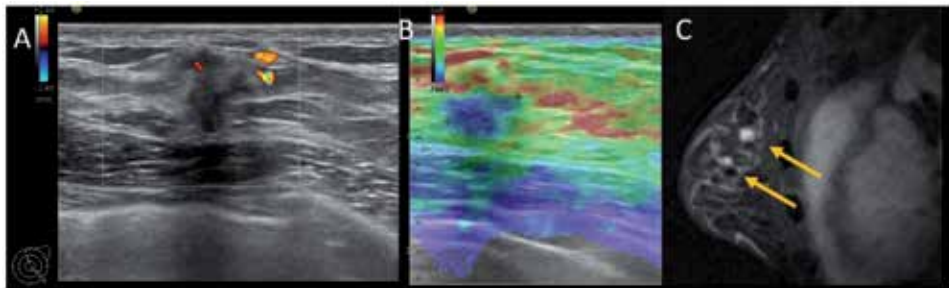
A breast lesion with suspect features was detected at US and proven to be an ILC (AB). The following staging MRI highlighted not one, but two lesions (C), concluding that one of the lesions was US occult.
